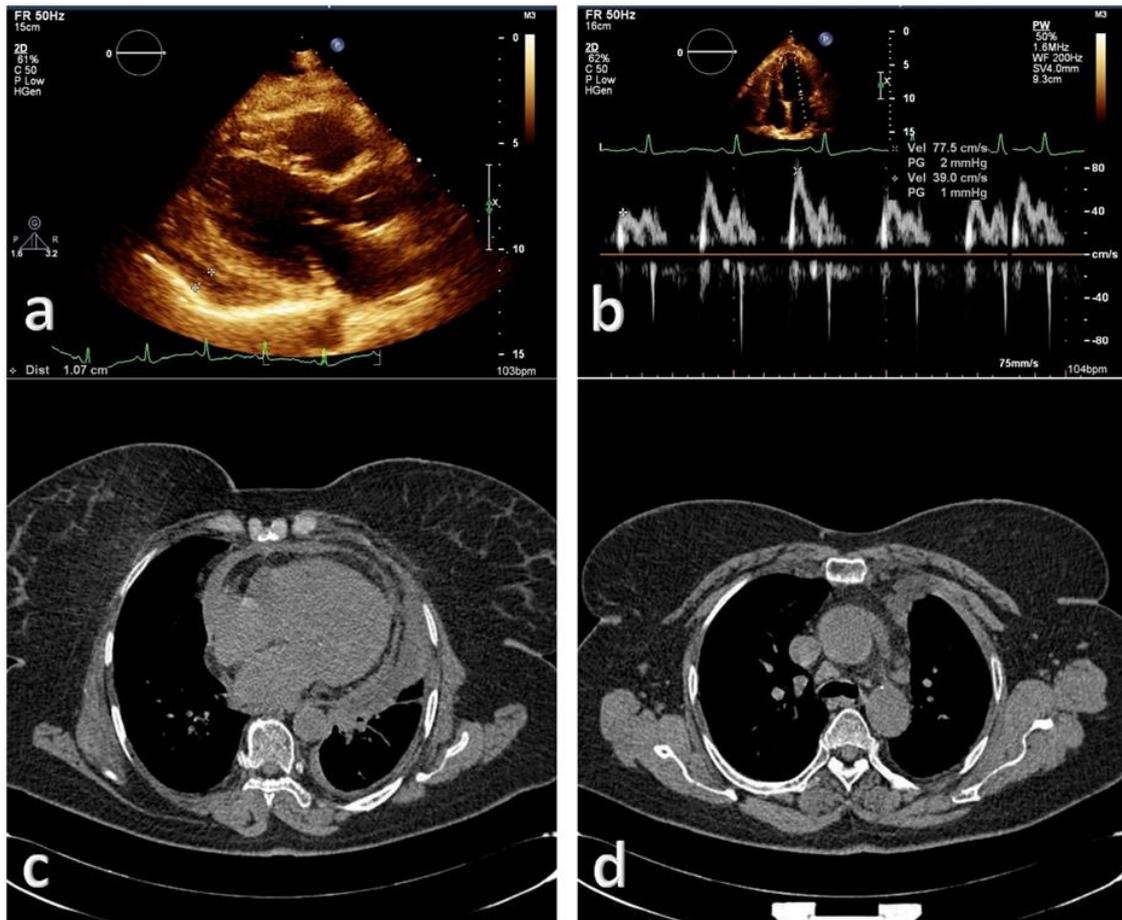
1a. Parasternal long axis view reveals small circumferential pericardial effusion and septal shudder. 1b. Pulse wave Doppler of mitral inflow shows significant respiratory variation. 1c. Mid thoracic slice of chest CT shows thick pericardium, small pericardial and pleural effusions. 1d. Upper thoracic chest CT shows multiple small perihilar and mediastinal lymphadenopathies.
